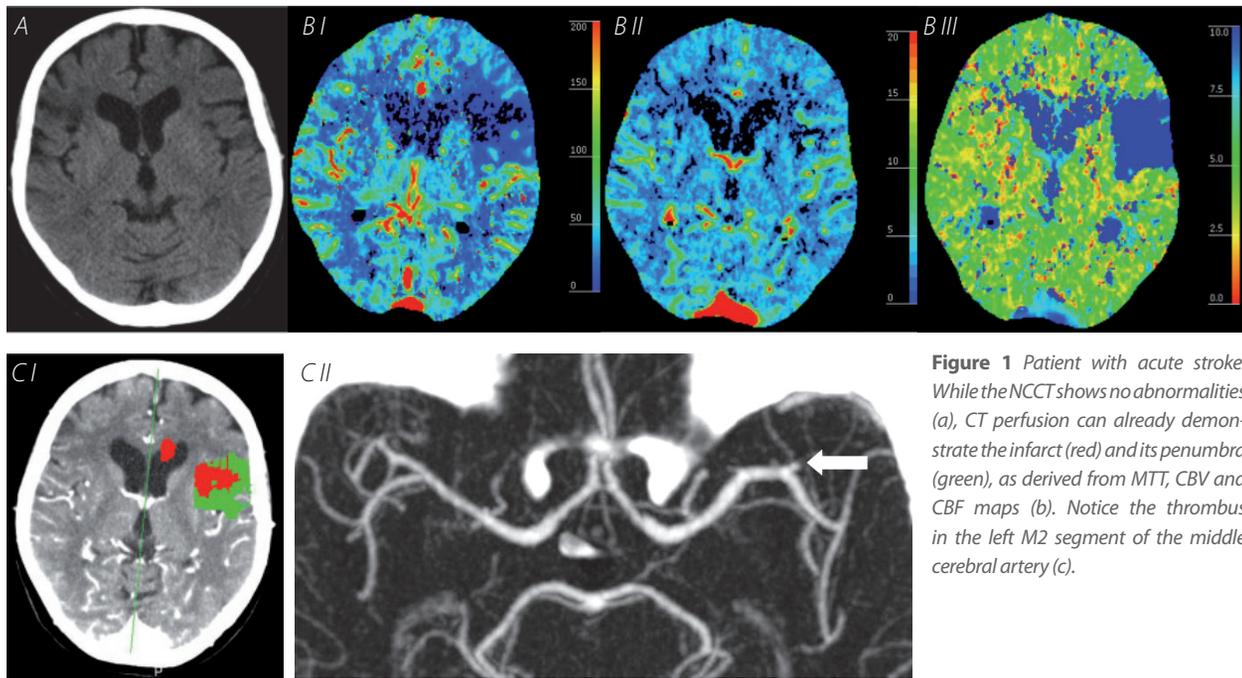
Patient with acute stroke. While the NCCT shows no abnormalities (a), CT perfusion can already demonstrate the infarct (red) and its penumbra (green), as derived from MTT, CBV and CBF maps (b). Notice the thrombus in the left M2 segment of the middle cerebral artery (c).
